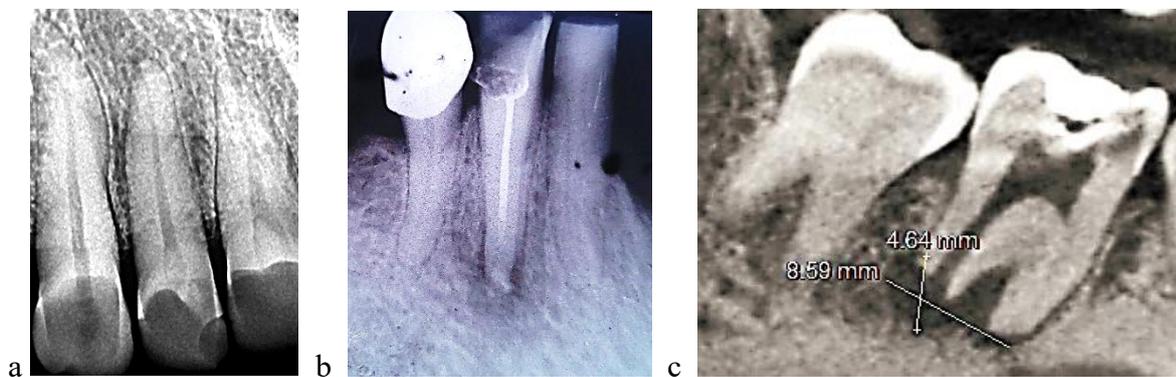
Radiograph of tooth 12 without signs of resorption (a). Radiograph of tooth 42 with signs of moderate resorption (b). CBCT section of tooth 47 with signs of severe resorption (c).
